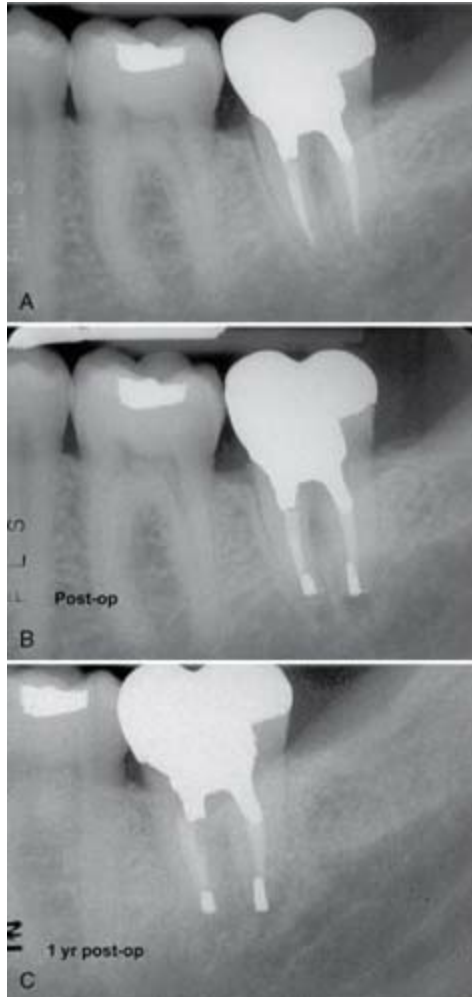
Intentional replantation. A, Preoperative radiograph of a mandibular left second molar. The tooth was persistently sensitive to percussion and biting after nonsurgical retreatment. B, Radiograph of the tooth immediately after extraction, root-end preparation and filling, and replantation. C, At the 1-year follow-up visit, the tooth was asymptomatic and showed good periradicular healing.
